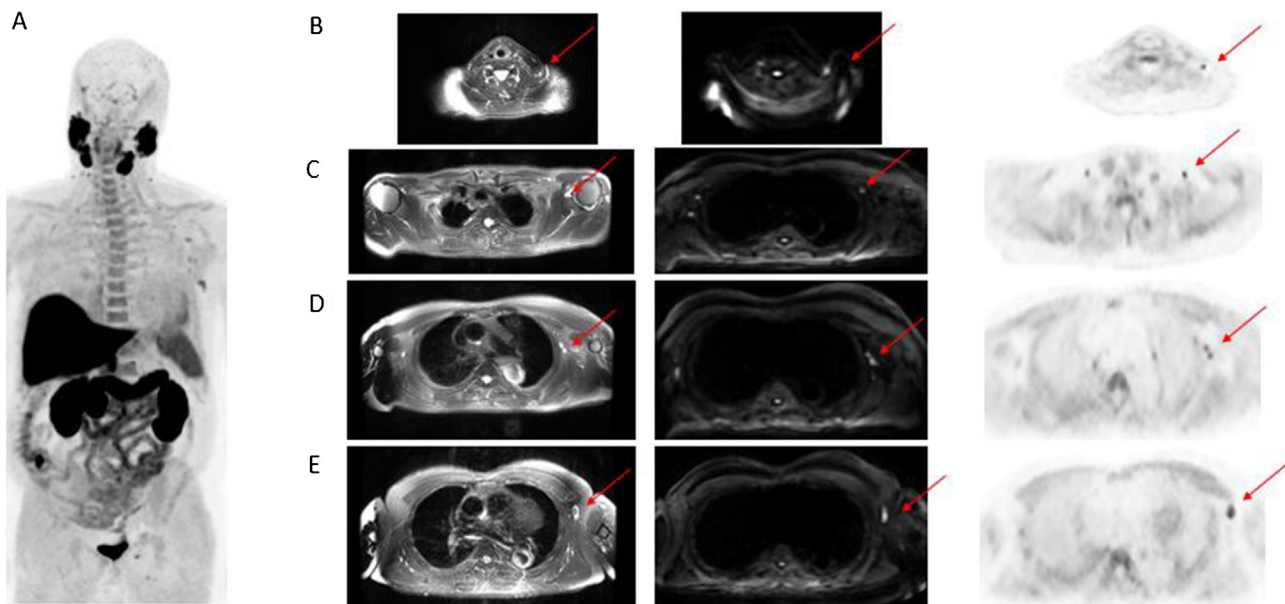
Whole-body MIP image (A). Selected axial PET/MRI images: T2 MRI, diffusion MRI sequence, [^{18}F]F-Choline. Clavicle fossa (B). Axilla (C–E). Infracentimetric lymph nodes, with [^{18}F]F-Choline uptake and diffusion restriction, found in left clavicle fossa and at the three levels of the left axilla.
